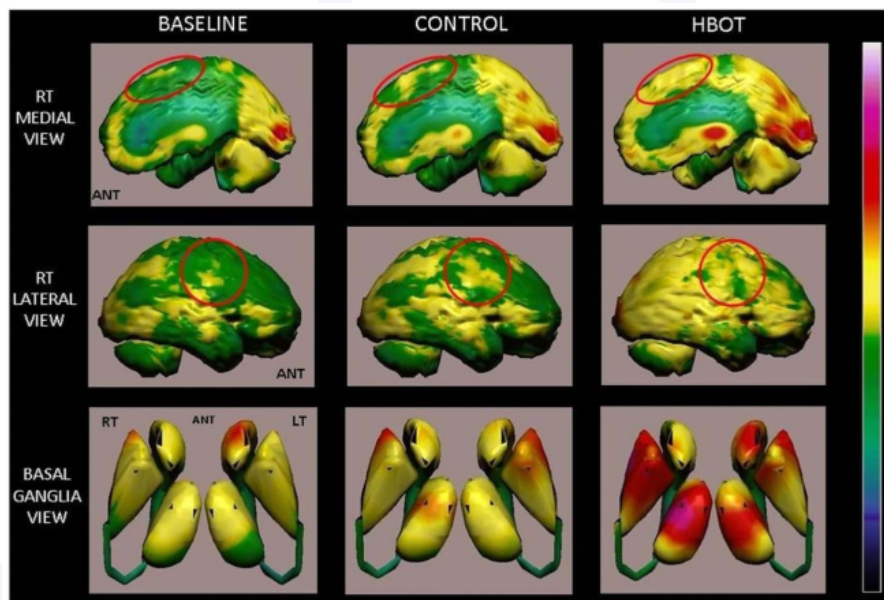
Volume rendered Brain SPECT perfusion maps following HBOT.
